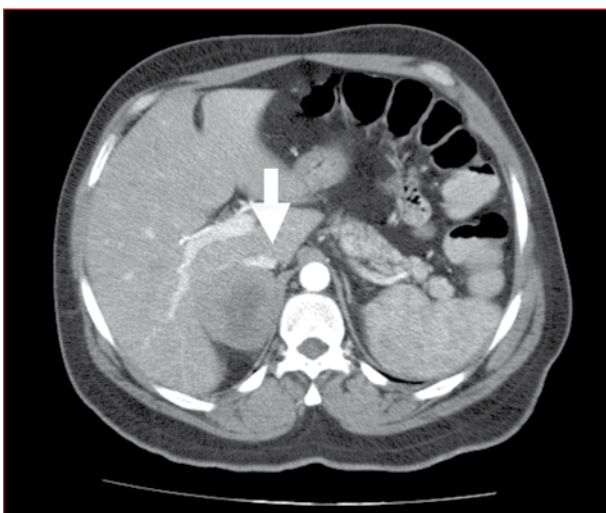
Contrast-enhanced computed tomography showing a large, right adrenal mass (arrow) with a central region of low enhancement
